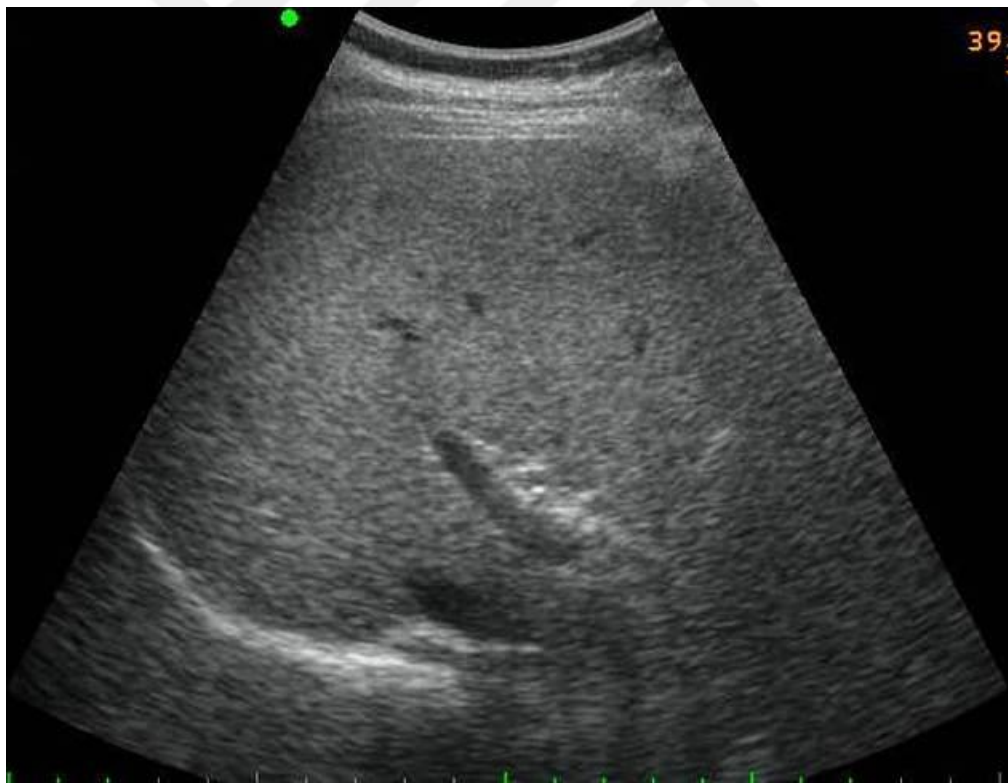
Ultrasound of human healthy liver with no preliminary diseases [38].
